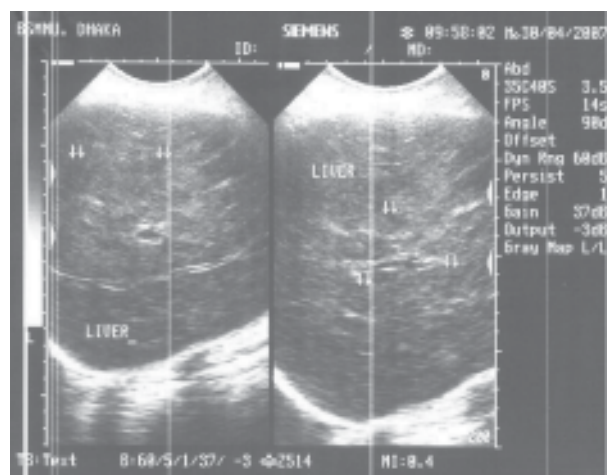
Sonographic image showing multiple mixed echogenic metastatic lesions of the right lobe of liver of a 55 years old male patient.
